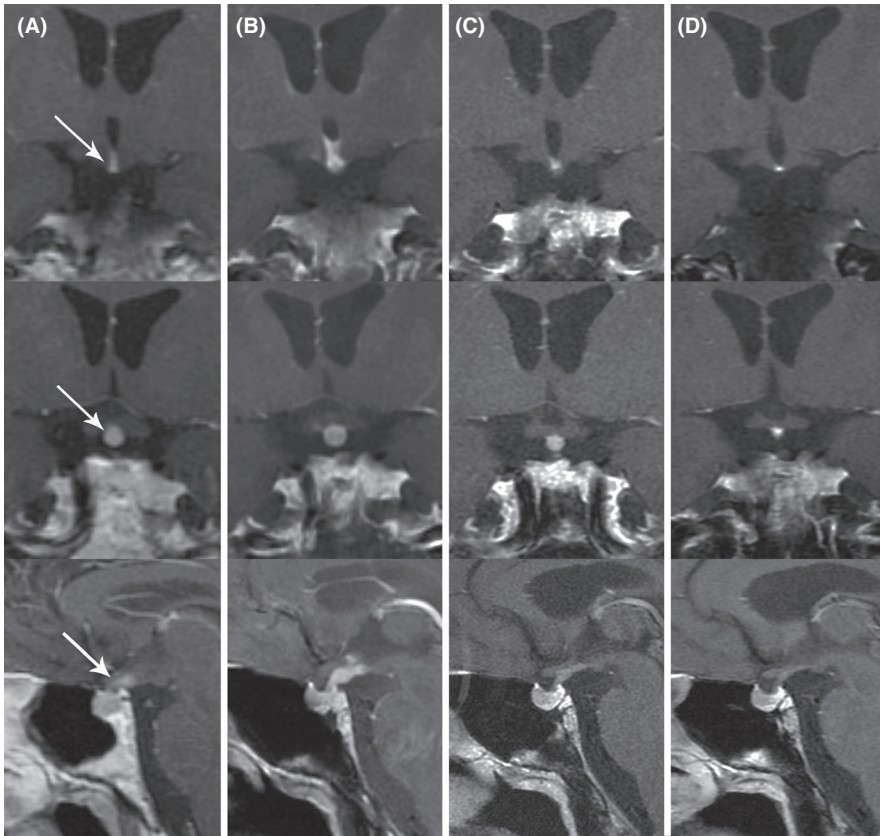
Magnetic resonance imaging of the pituitary gland. Postcontrast T1-weighted coronal and sagittal images at presentation (A), 5 mo later (B), and 3 mo (C), and 1 y (D) after ongoing treatment with ibrutinib was initiated
